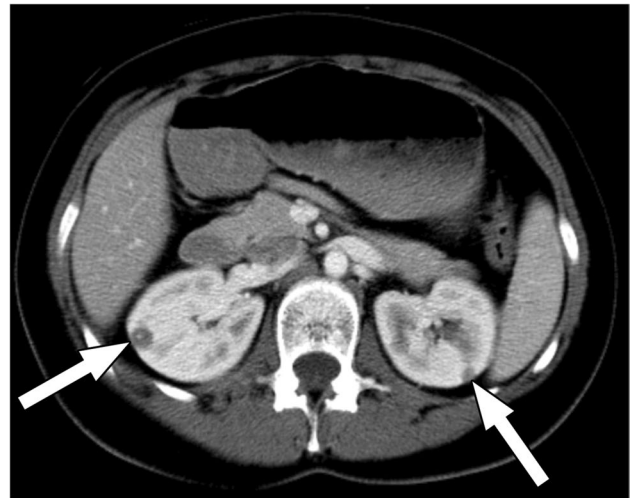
15-year-old girl with disseminated histoplasmosis and kidney involvement. Axial abdominal CT image with IV contrast material shows small round low attenuation lesions in both kidneys (arrows), the one on the right with a punctate central calcification. Additional images of the abdomen and chest from the same CT (not shown) demonstrated splenic calcifications, bilateral calcified lung nodules, and enlarged, calcified mediastinal lymph nodes typical of histoplasmosis
